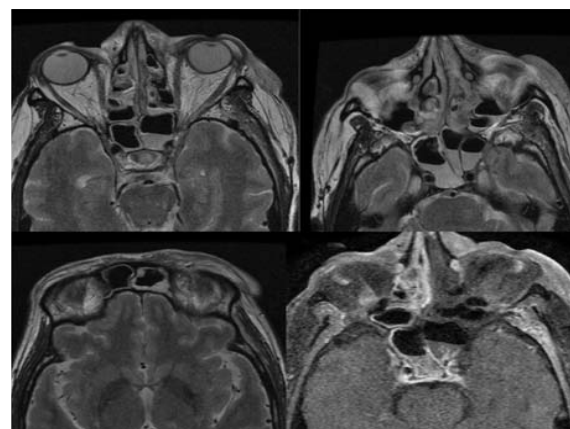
Axial T2 FSE image of paranasal sinuses along with orbital cuts shows pansinusitis. Axial T1 contrast image of paranasal sinuses showing diffuse avid mucosal enhancement along visualized section of sinuses. Follow up MRI 2 weeks after surgical debridement showed no relief in patient condition with following imaging findings.
